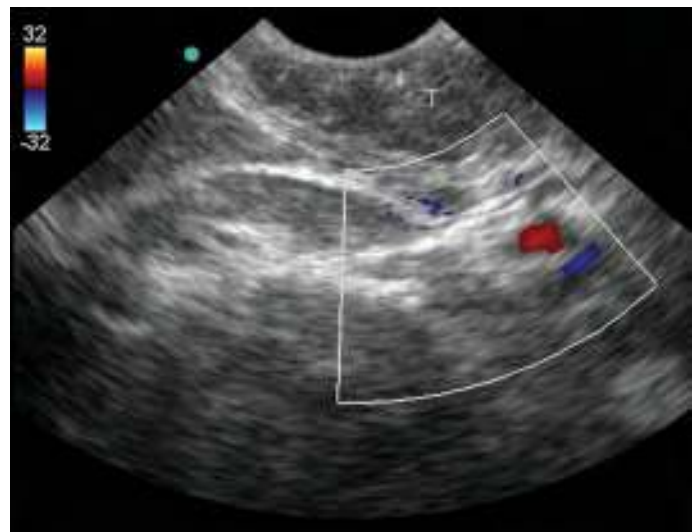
Transverse color Doppler scan of the normal posterior pharynx. The tonsil (T) is visible on the top of the image. The internal carotid artery is noted by its red color Doppler signal.
